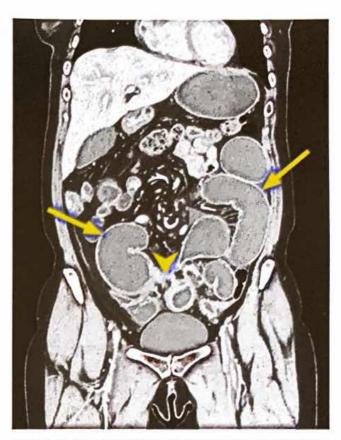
CT scan of the abdomen and pelvis in a patient with Crohn disease, showing small-bowel obstruction with dilated loops of small intestine (arrows) and matted loops of bowel (arrowhead) in the pelvis.
